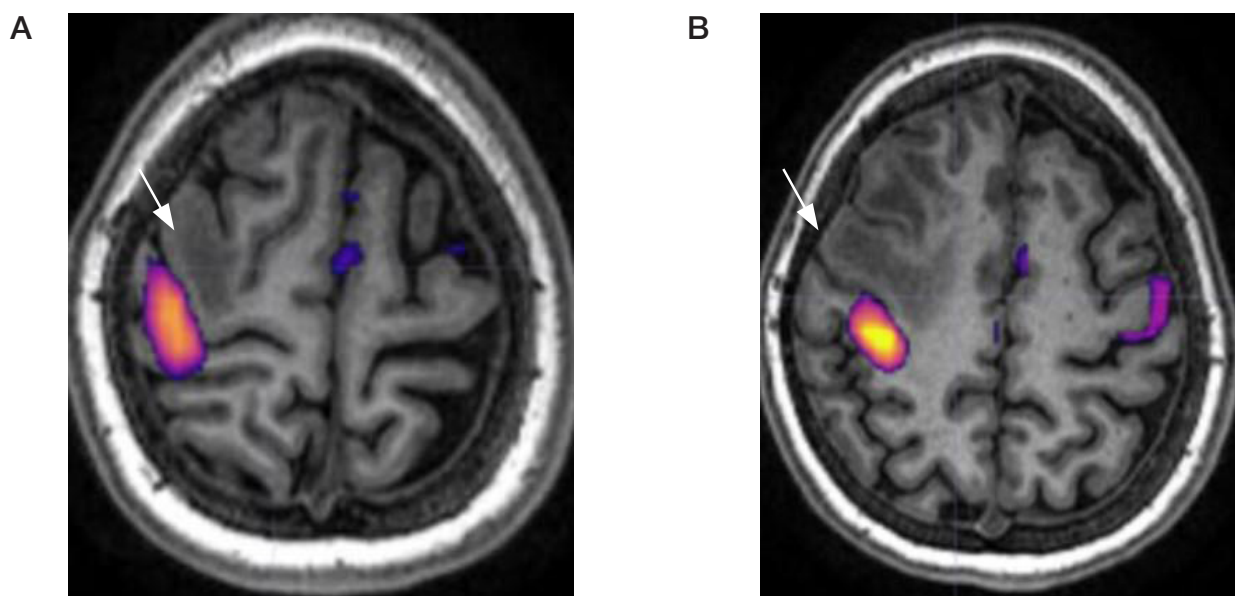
Functional MRI. Motor cortex mapping in patient with refractory epilepsy (A, B). Distribution of the areas showing activation when moving the left fingers is marked by the arrowhead, the epileptogenic zone is marked by the arrow
